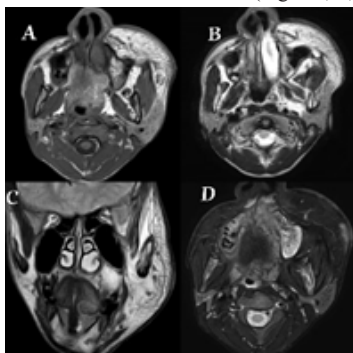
MRI FACE images, A. Axial T1, B. Axial T2, C. Coronal T2 Weighted images showing diffuse T1 & T2 hyperintense proliferated subcutaneous fat involving left hemiface which is showing suppression on T1 Fat Saturation (image D).
